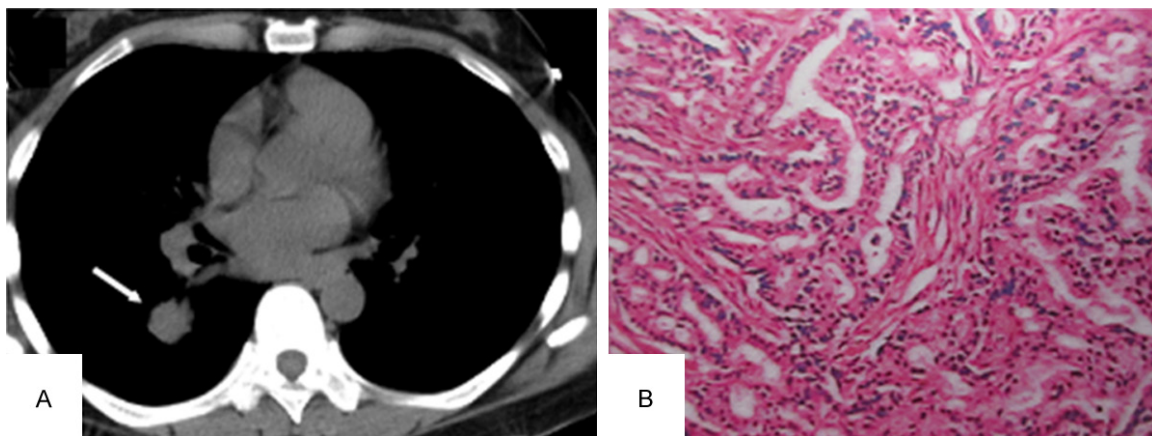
A. Preoperative computed tomography (CT) of the lung revealed a solitary nodule in the right lower lobe. B. Moderately differentiated pulmonary adenocarcinoma in tumor tissue obtained during surgery (HE, ×100).
